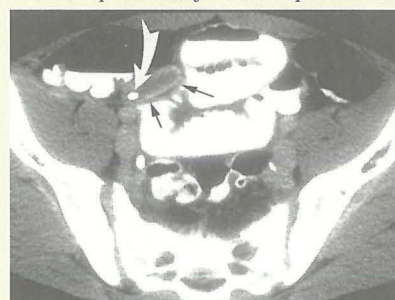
CT scan showing an inflamed appendix in longitudinal section (straight arrows) which contains an appendicolith (curved arrow).
